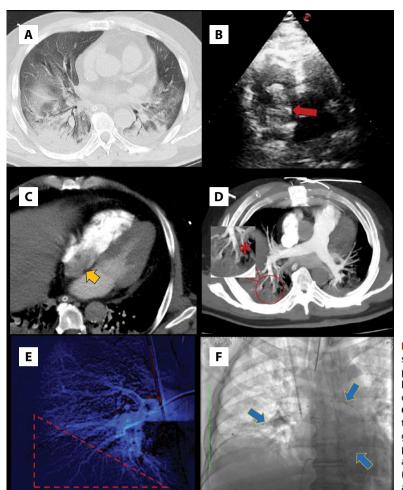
A. Chest computed tomography scan showing ground-glass opacities and crazy paving pattern in lower lobes associated with posterior basal consolidations. B. Transthoracic echocardiogram signalling the thrombus (red arrow). C. Four-chamber computed tomography signalling the thrombus (yellow arrow). D. Computed tomography pulmonary angiography demonstrating the pulmonary embolus (red asterisk). E. Pulmonary angiography demonstrating a hypoperfused area (dotted triangle). F. EKOS catheter inside the right atrium and right pulmonary artery (blue arrows)
